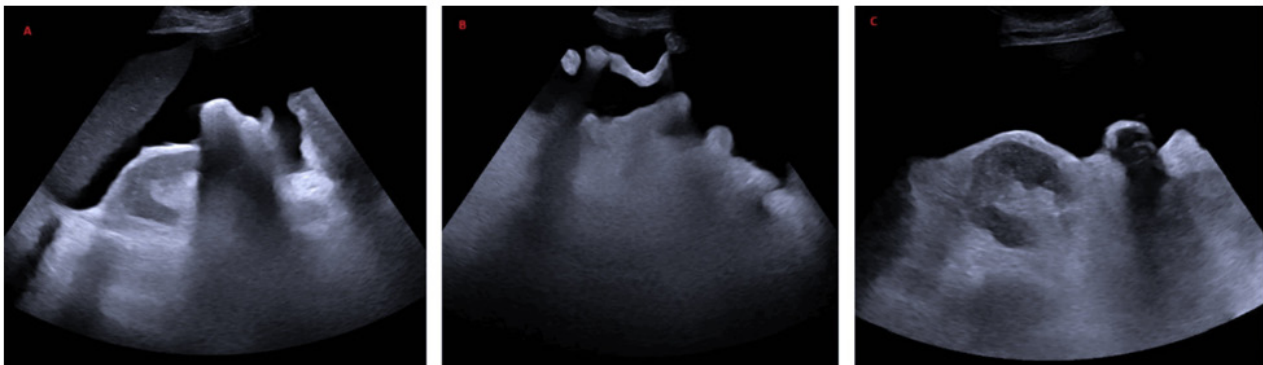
Admission abdominal ultrasound demonstrating gross ascites (A) Right upper quadrant view showing the liver and right kidney with a large volume of surrounding anechoic free fluid (B) Left iliac fossa view demonstrating marked free fluid tracking within the lower abdomen (C) Left kidney view with adjacent anechoic ascitic fluid confirming generalised intra-abdominal accumulation.
